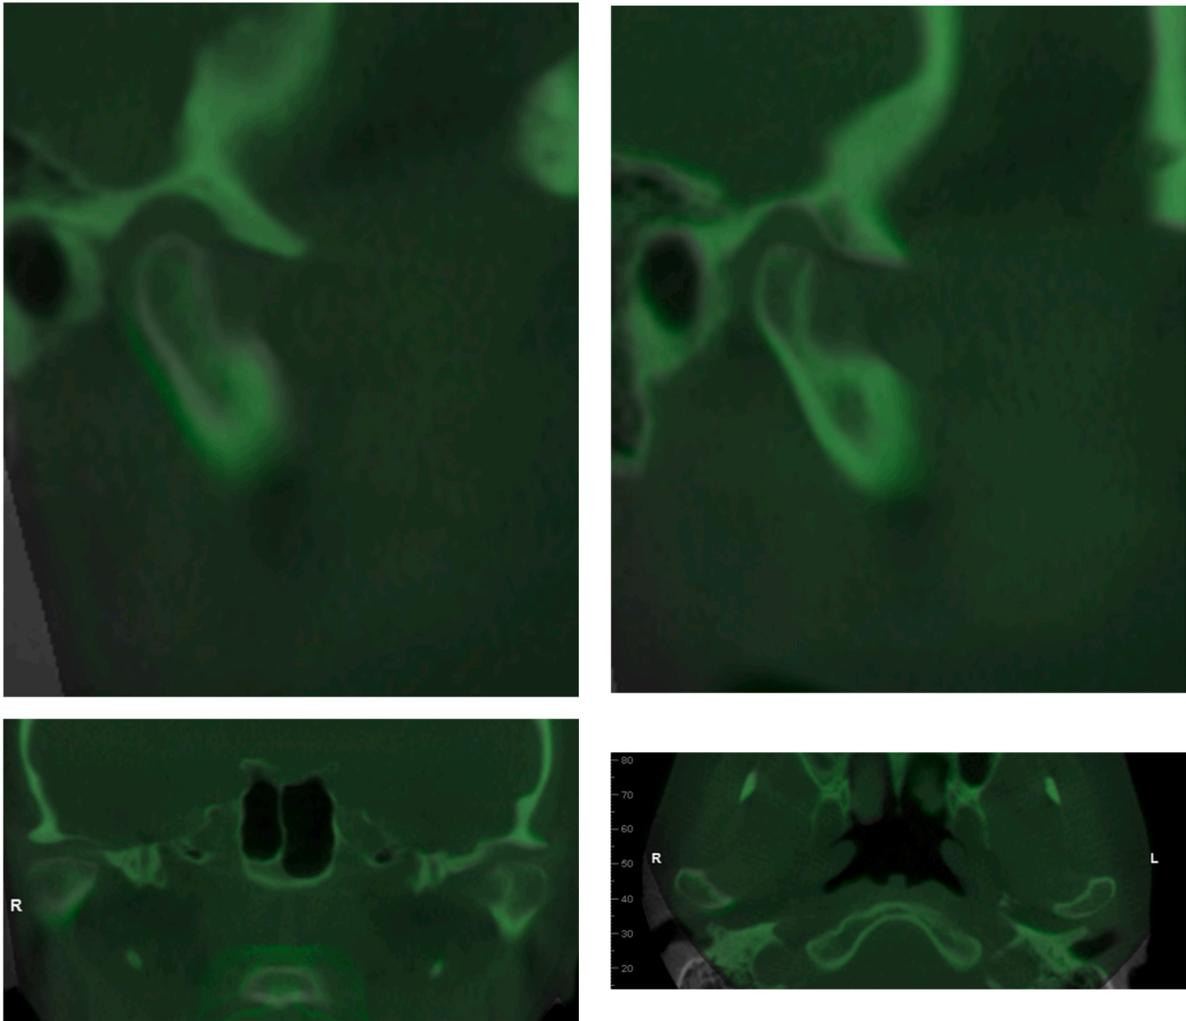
Superimposition of initial presentation (gray) and post-procedure (green) CBCT. Post-procedure CBCT was taken with tight elastic intermaxillary fixation to ensure accurate analysis of post-procedural condylar position. A. Right sagittal view demonstrating inferior displacement of the condyle in the post-procedure CBCT. B. Left sagittal view showing minimal positional change. C. Coronal view showing inferior condylar displacement on the right, consistent with the right sagittal view. D. Axial view.
